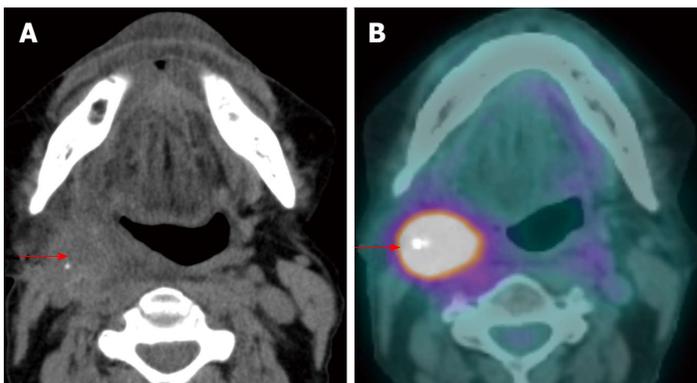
Recurrent nodal disease. A T2N1M0 right hypopharyngeal squamous cell carcinoma status post completed chemoradiation 2.5 years ago with complete response (not shown). The patient presented with right sided level II lymphadenopathy. Computed tomography (CT) without contrast (A) showed an ill-defined mass in the right level II. Positron emission tomography/CT (PET/CT) (red arrow) (B) demonstrated very intense metabolism in the mass. Biopsy confirmed a recurrent squamous cell carcinoma in the right level II a node.
